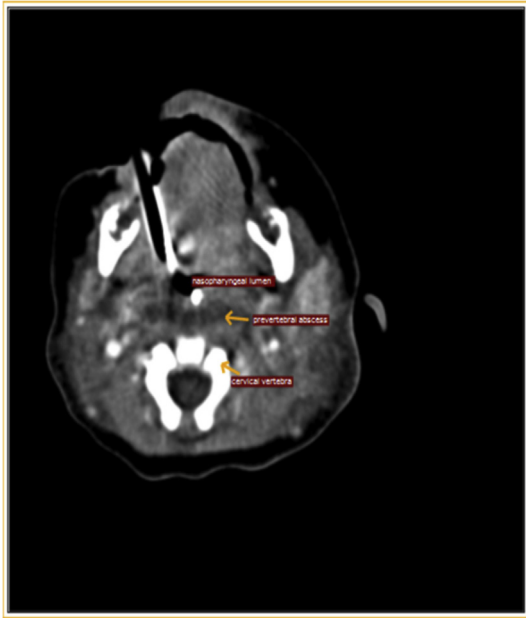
Axial CT section showing retropharyngeal abscess.
